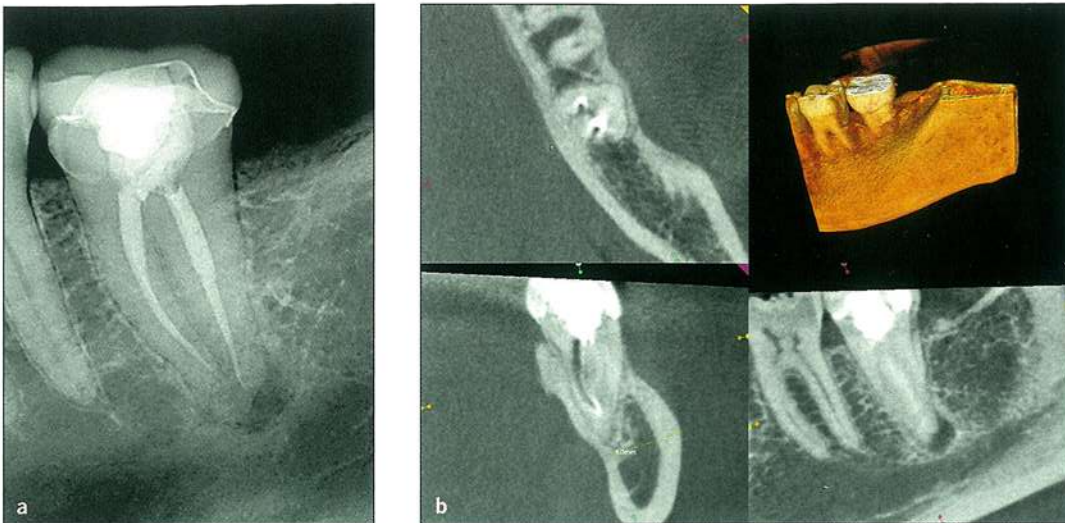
(a) 2D planar view. (b) CBCT scan. (c) Postoperative radiograph showing treatment of the untreated mesio-buccal canal. (d) Six-month follow-up radiograph showing initial healing.
